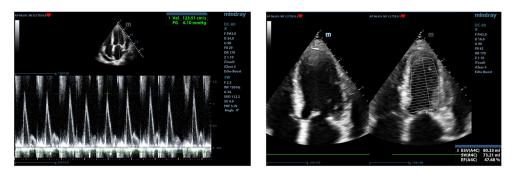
c.5. Evaluation of diastolic (left: transmitral valves PW Doppler, E wave respiratory variations of 13%; apical 4-chambers view) and systolic function (right: LVEF 47%, apical 4-chambers view) of the left ventricle in the presented case
